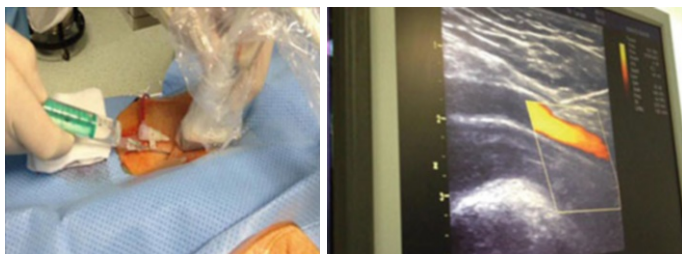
Ultrasound-guided femoral vessel access using a linear probe. The pulsating flow of the femoral artery and the needle directing towards the femoral artery are seen
